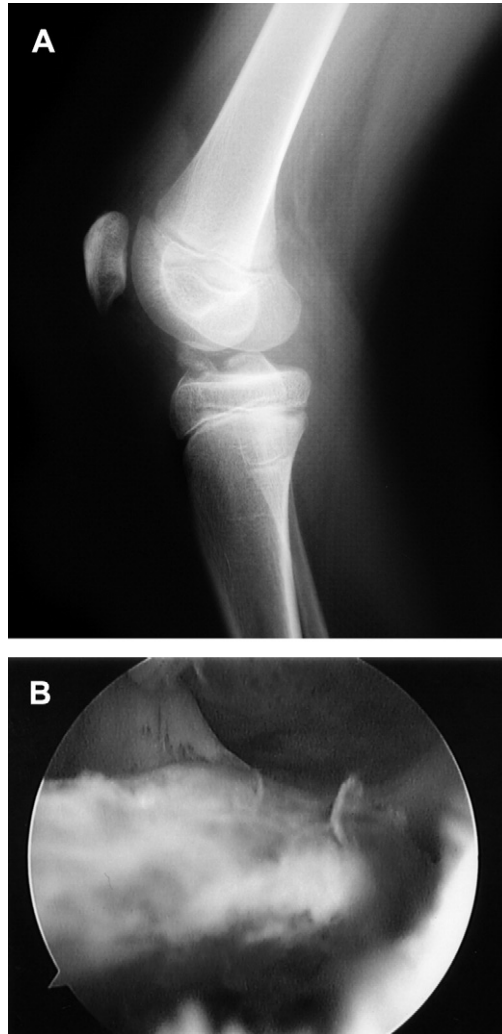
(A) This lateral radiograph demonstrates a type IIIIB tibial spine fracture in a 12-year-old male. (B) This arthroscopic view shows the type IIIIB tibial spine fracture after the entrapped intermeniscal ligament was retracted with a 2-0 Prolene suture.
